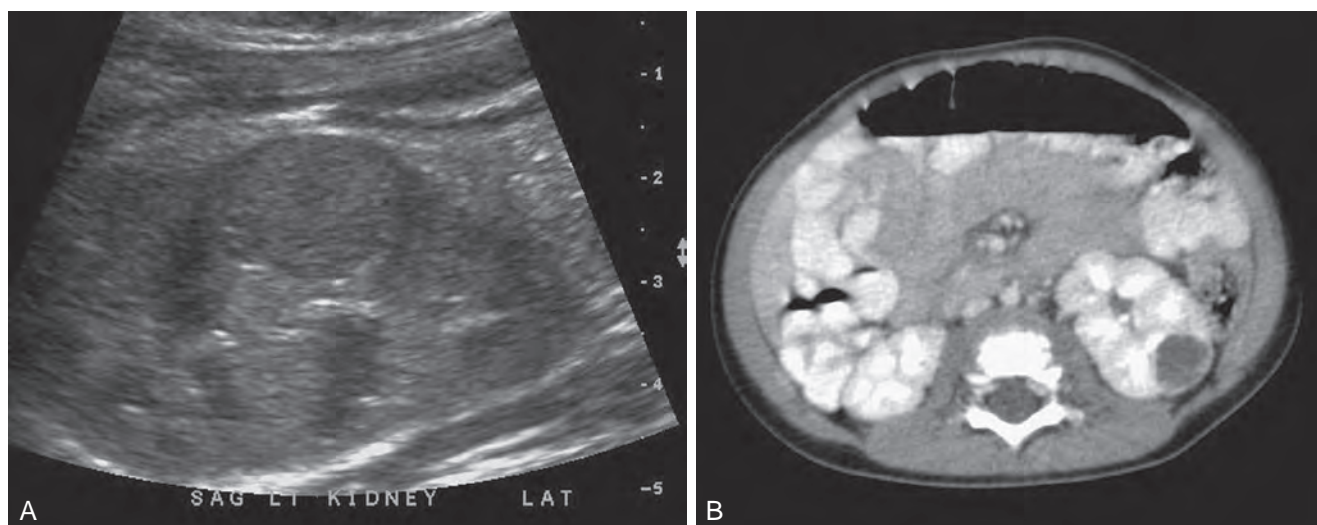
Small renal tumor found on serial screening. A, Ultrasound scan shows solid lesion just pushing out from the cortex. B, Computed tomography demonstrates that lesion is amenable to renal-sparing surgery.
